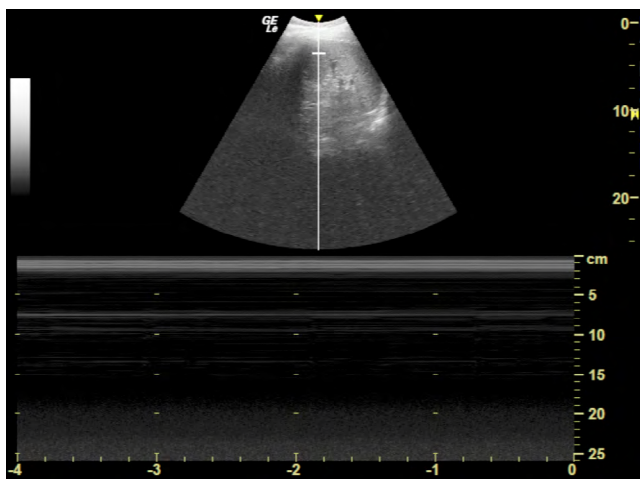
M-mode diaphragm ultrasound image.
